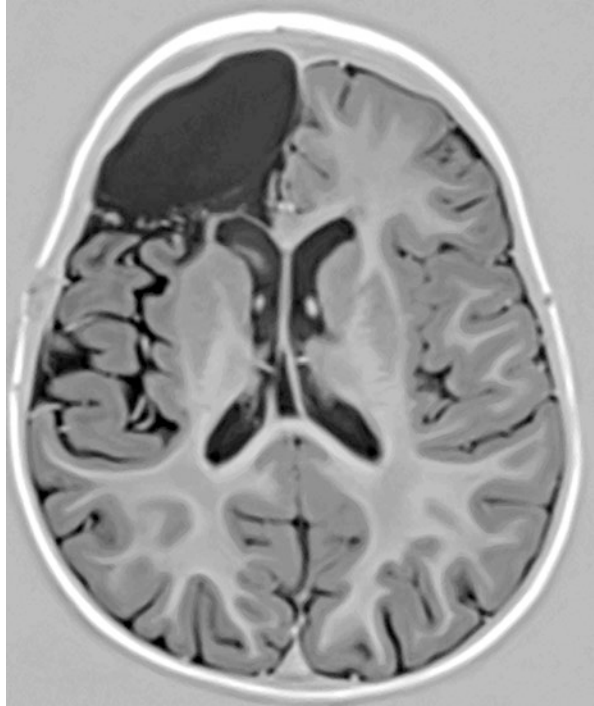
Post surgical MRI shows the extent of the right frontal lobectomy. The patient is seizure free
